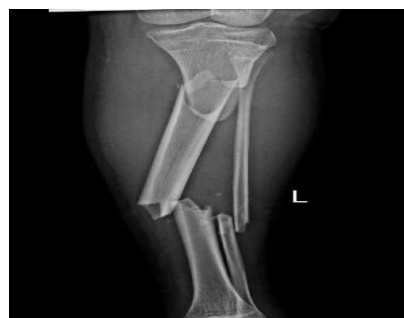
Preoperative anteroposterior (AP) radiograph of the tibia
